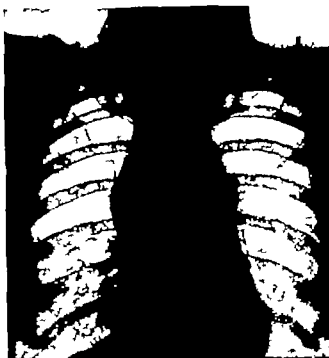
(a)—Radiograph of the chest showing a large mass in the mediastinum (see text)
